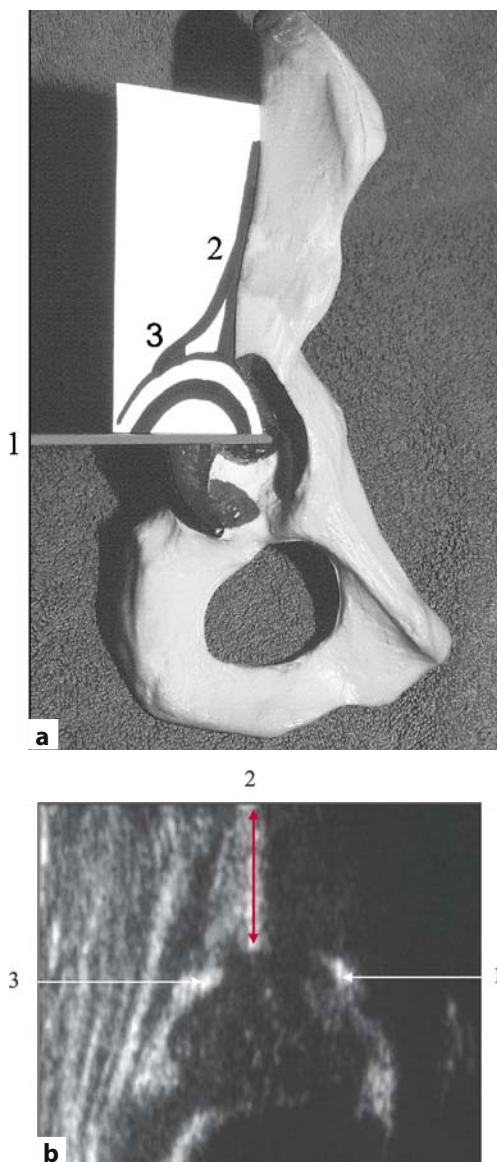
a The sonographic image of the infant hip in the coronal plane has three landmarks: 1, lower limb of os ilium as rotating axis for the sectional plane; 2, mid part of the acetabular roof (standard sectional plane); 3, acetabular labrum. b 1, lower limb of the os ilium; 2, correct plane; 3, labrum
